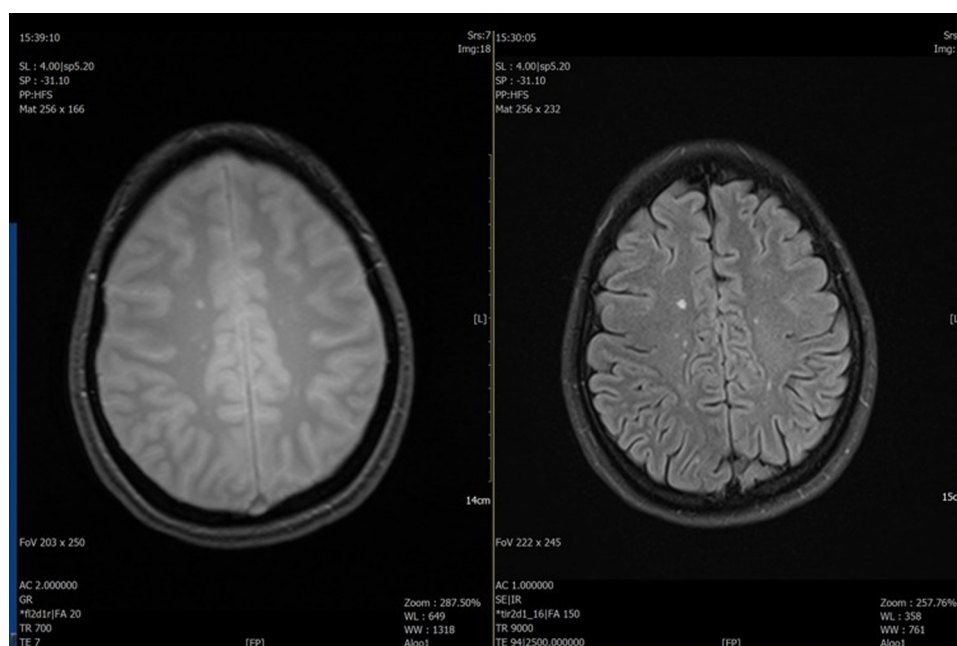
MRI of a patient that has demyelinating lesions in the cortex in presence of a peripheral facial palsy.
